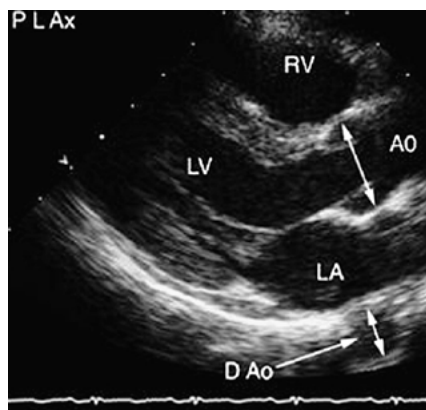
2-D echocardiography in the parasternal long axis view. LV= left ventricle, RV= right ventricle, LA= left atrium, Ao= aorta, D Ao = descending aorta
